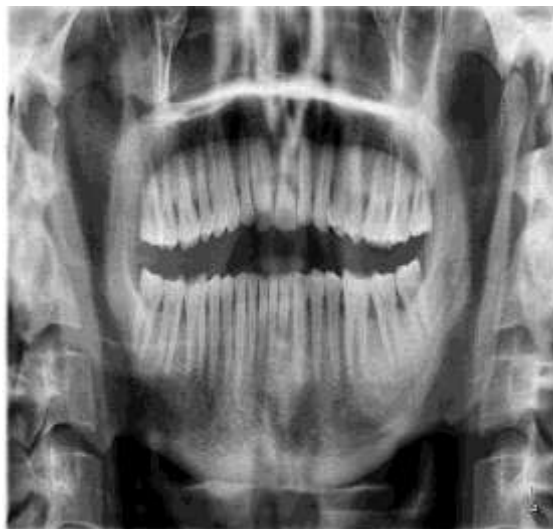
Panoramic radiograph showing a well-defined radiolucency of 3x3 cm extending from medial side of condyle to lateral side of coronoid process antero-posteriorly and till middle of right ramus inferiorly
